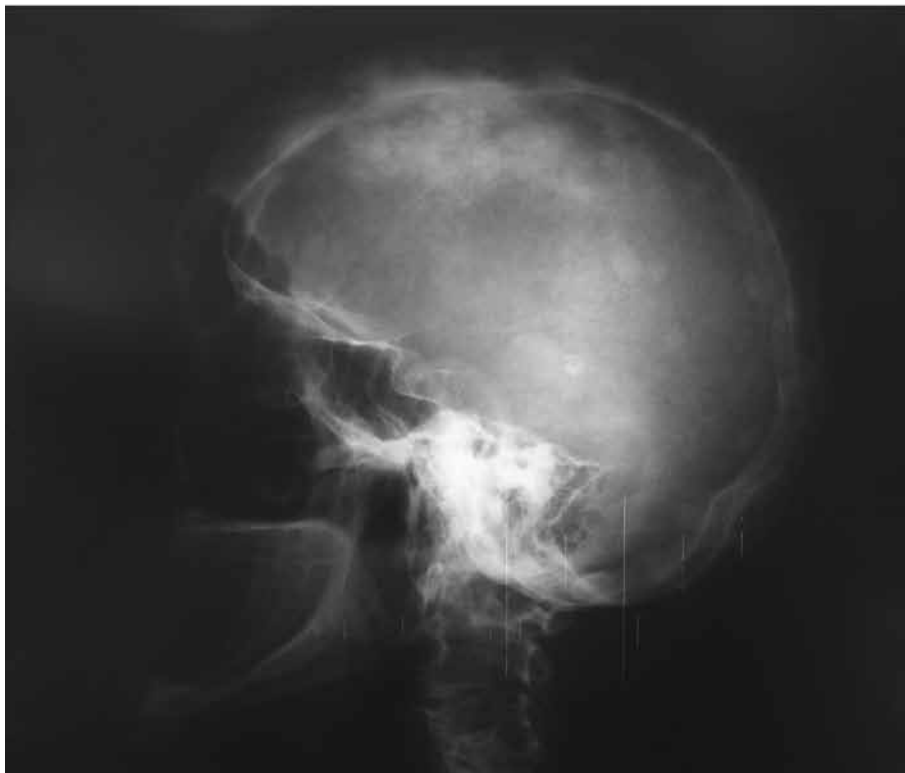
Bone scintigraphy showing polyostotic Paget's disease of bone with enhanced tracer uptake more prominently on skull, pelvis and spine, and dispersed degenerative articular lesions before zoledronic acid infusion; B. Radiograph of the skull showing a 'cotton-wool' appearance indicative of the sclerotic phase of Paget's disease of bone
